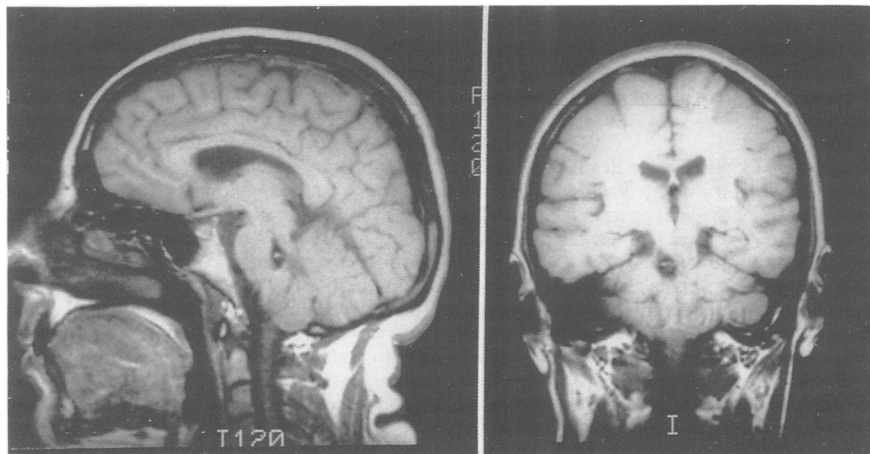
Figure Axial and sagittal T<sub>1</sub> MRI showing a cavernous angioma in the right dorsal part of the pons.
